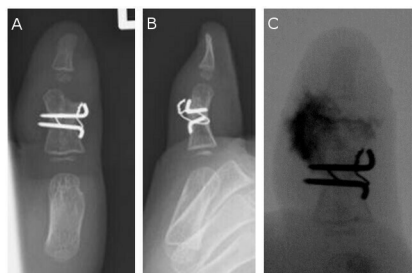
Radiographs 7 months after the costal osteochondral graft. (A and B) Radiographs before the implant removal. The graft is fused with graft bed. (C) Arthrography shows that the articular surface is continuous.
